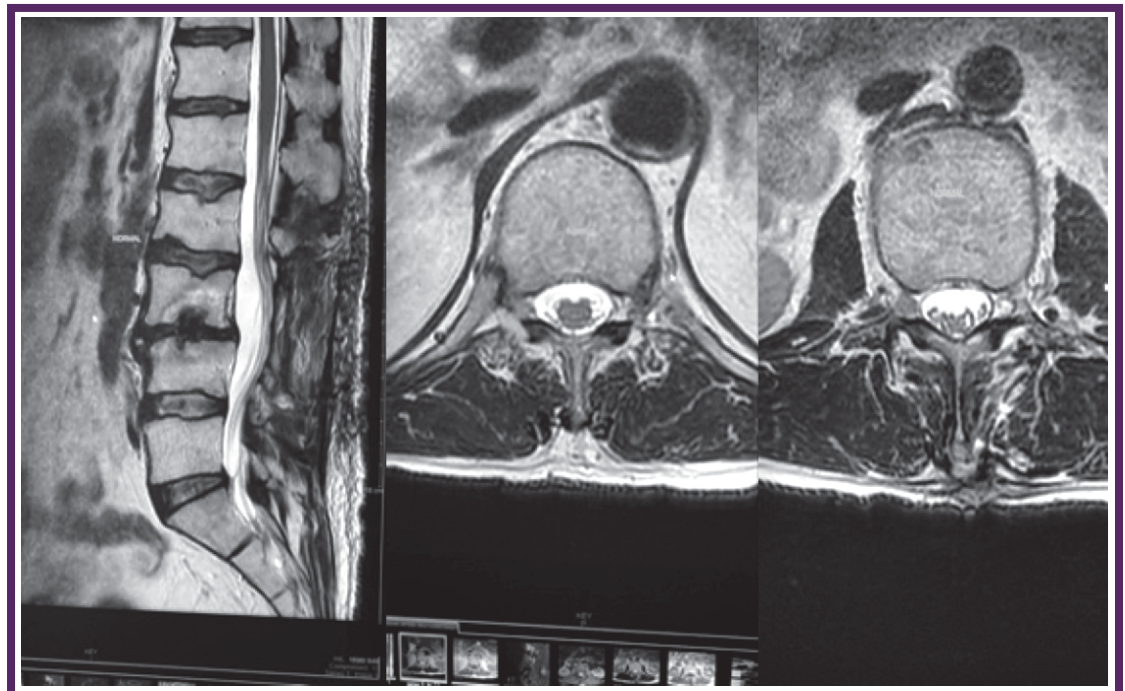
Normal radiographs of the spinal cord in both sagittal and transverse planes
